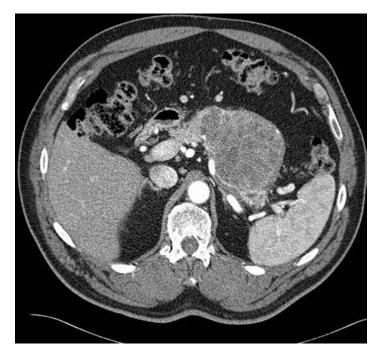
CT scan image of a large serous cystadenoma in the tail of the pancreas
